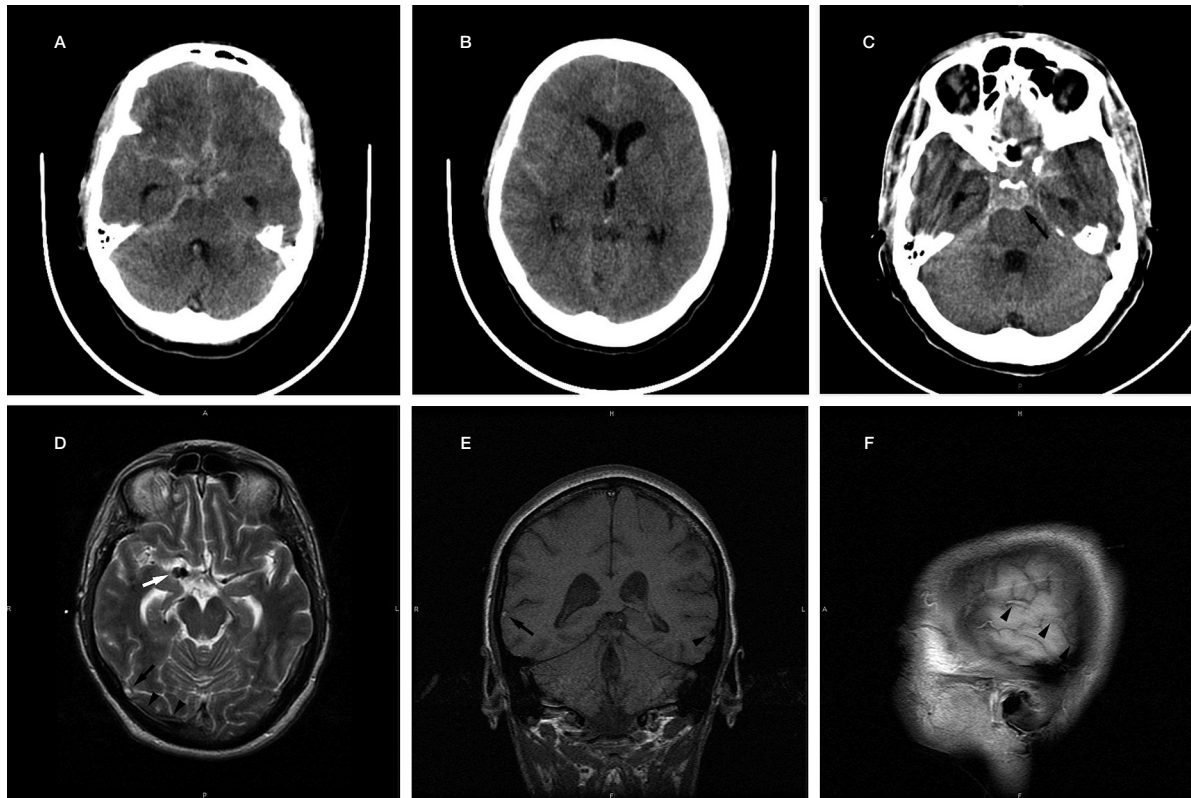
Uncontrasted axial CT images demonstrating (A) extensive acute subarachnoid blood particularly in the basal cisterns, (B) extending into ventricles and the cortical sulci of the right cerebral convexity. (C) A repeat uncontrasted CT study 12 hours post-coiling showing an acute rebleed, predominantly in the pontine cistern (arrow). Axial T2- (D), Coronal T1- (E) and Sagittal T1- (F) weighted MR acquisitions immediately post-coiling. D) Hyperintense signalled thrombus is seen at the confluence of the right anastomotic vein of Labbe (black arrow) with the right transverse sinus (arrowheads). Note the susceptibility artefact from the coiled right PComA aneurysm (white arrow). E) T1-weighted shortening of the right anastomotic vein of Labbe (arrow) in contradistinction to the signal within the left vein (arrowhead). F) T1-weighted shortening of the right anastomotic vein of Labbe on a right parasagittal section.
